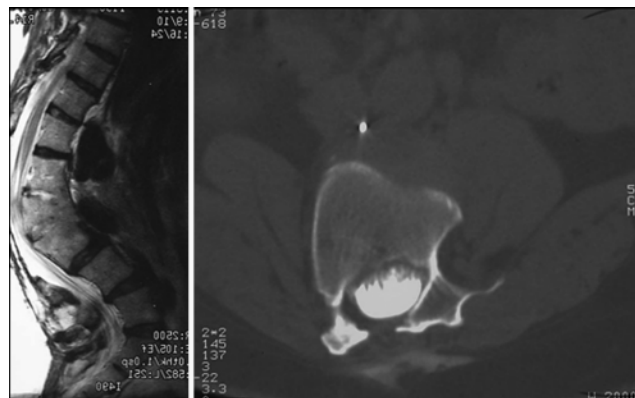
Case 2. Preoperative sagittal (left) and axial (right) T2-weighted MR images. Note the cauda equina draped over posterior aspect of VB at the apex of the curve. This focal lumbar kyphosis is well suited to a PSO at the apex.
